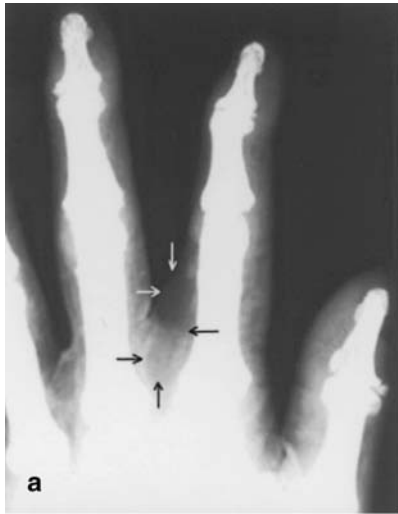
Lipoma. a Low-kilovoltage plain radiograph. b Axial T1-weighted SE image (TR/TE/slice thickness: 420 ms/15 ms/4 mm). c Axial ultrasound image. Homogeneous well-delineated mass (*arrows*) between the flexor tendons (*asterisks*) of second to third fingers isointense and slightly hypoechogenic to subcutaneous fat. *p* phalanx
